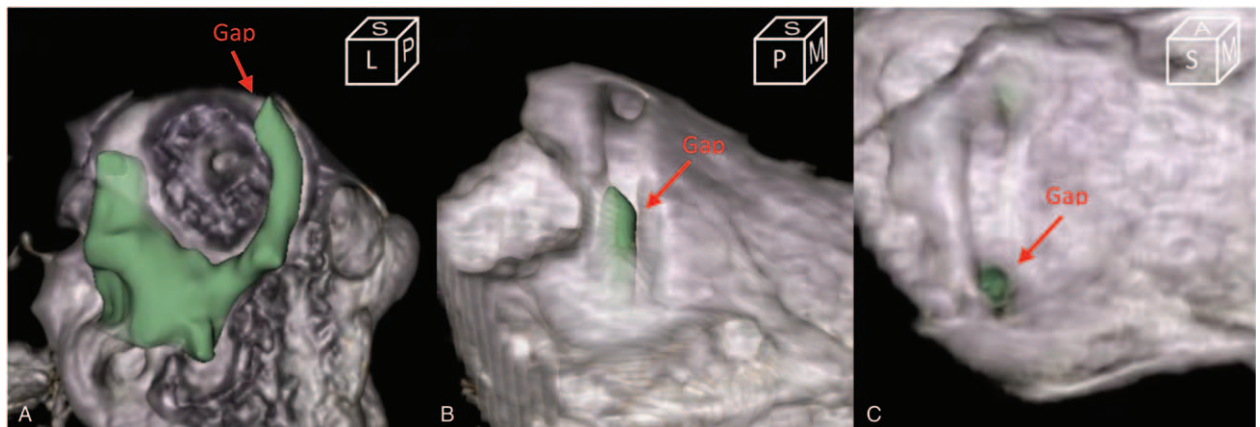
Combined 3D reconstruction of CT and MRI imaging following SCD repair. 33-year-old man with left ear SCD following SSC plugging via MFC (same patient as in Fig. 2 [patient B]). A residual defect is noted in the posterior limb on combined 3D reconstruction of CT and MRI imaging. T2-weighted MRI signal represents the fluid in the SSC with the surrounding bony CT. A, parallel view of SSC (Pöschl view). B, posterior–superior view of SSC. C, Superior view of SSC. A indicates anterior; CT, computed tomography; L, lateral; M, medial; MRI, magnetic resonance imaging; P, posterior; S, superior; SCD, superior canal dehiscence; SSC, superior semicircular canal.
